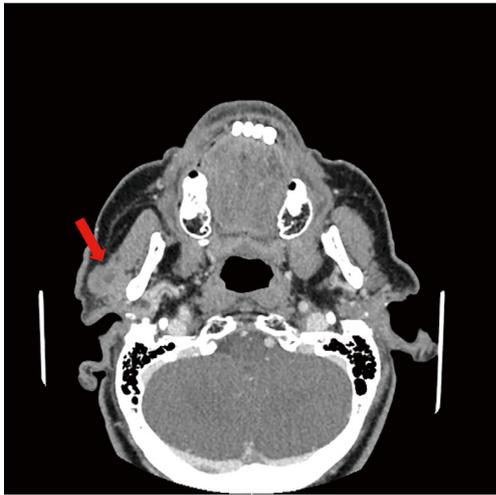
CT with contrast, axial scan. Red arrow shows tumor arising from the right parotid gland limited to the superficial flap. CT, computed tomography.
